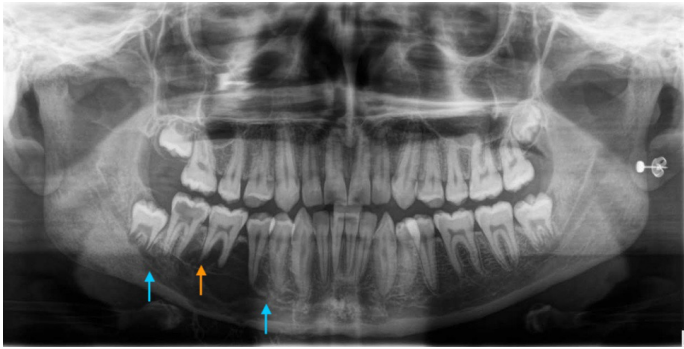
Preoperative mandible orthopantomogram: a multiloculated radiolucency is seen in the right mandibular body associated with teeth 44–47 (blue arrows). Evidence of root resorption of 46 is seen (orange arrow). Expansion of the lesion into the soft tissue seen by the calcified margins of the lesion inferior to the mandibular border
